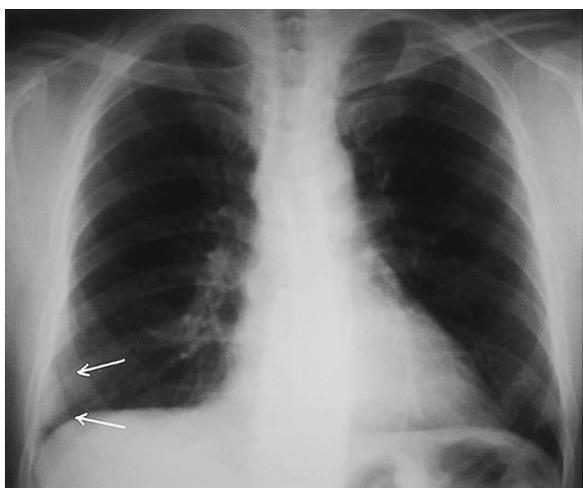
Roentgenogram of the chest shows an abnormal shadow of the right lower lateral chest wall. No pleural effusion is seen.
